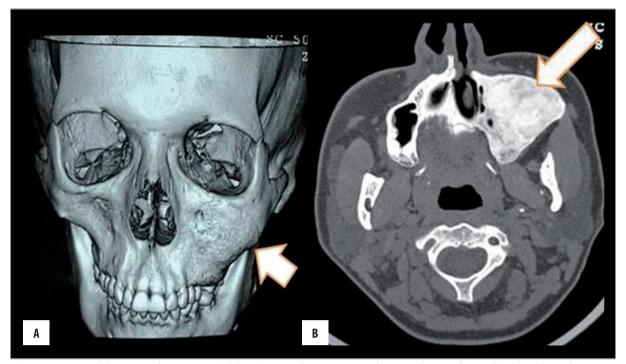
A 27-year-old woman with monostotic FD. (A) 3D-CT image showing anexpansile osseous lesion in the maxillary bone (short white arrow), and (B) unenhanced axial CT on bone window showing a sclerotic pattern (long white arrow).
